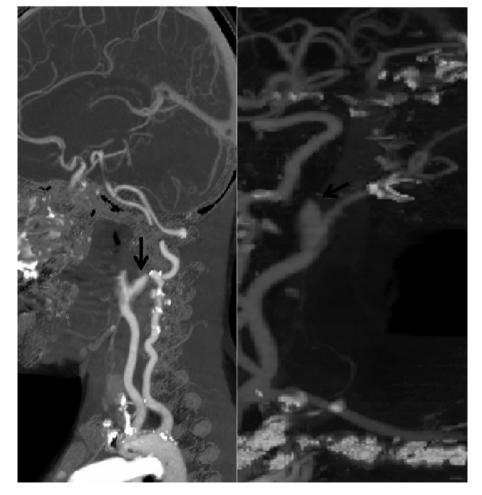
(A and B) CT angiography reconstructed images demonstrating the "Flame shaped" occlusion of the left internal carotid artery 1 cm distal to its origin suggestive of dissection (arrows).
